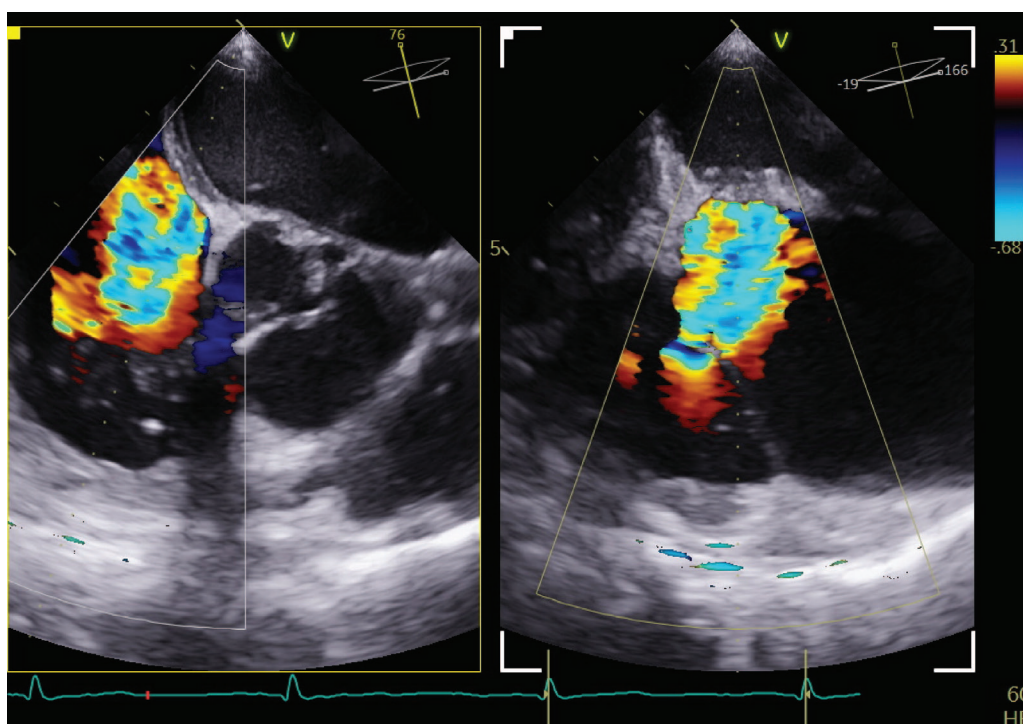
Transesophageal echocardiography showing massive tricuspid regurgitation before transcatheter edge-to-edge repair.
